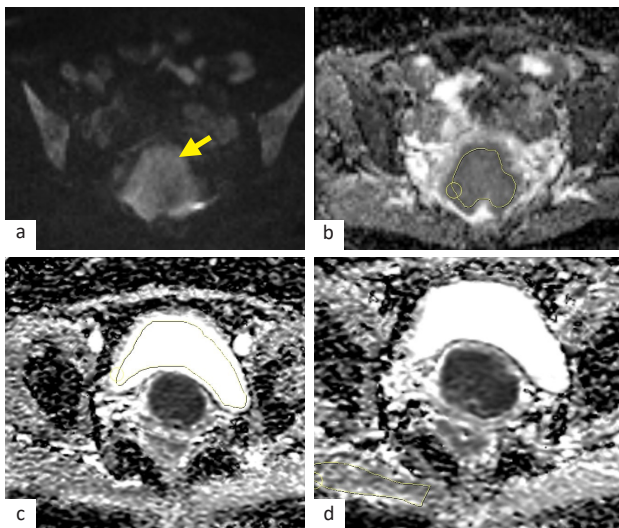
Diffusion MRI sequences on an axial plane in cervical cancer. (a) DWI with b-value = 1,000 s/mm² showed hyperintensity lesion within the tumor (yellow arrow); (b-d) ROI in the tumor, urinary bladder, and gluteal muscle. DWI=diffusion-weighted imaging; MRI=magnetic resonance imaging; ROI=region of interest
